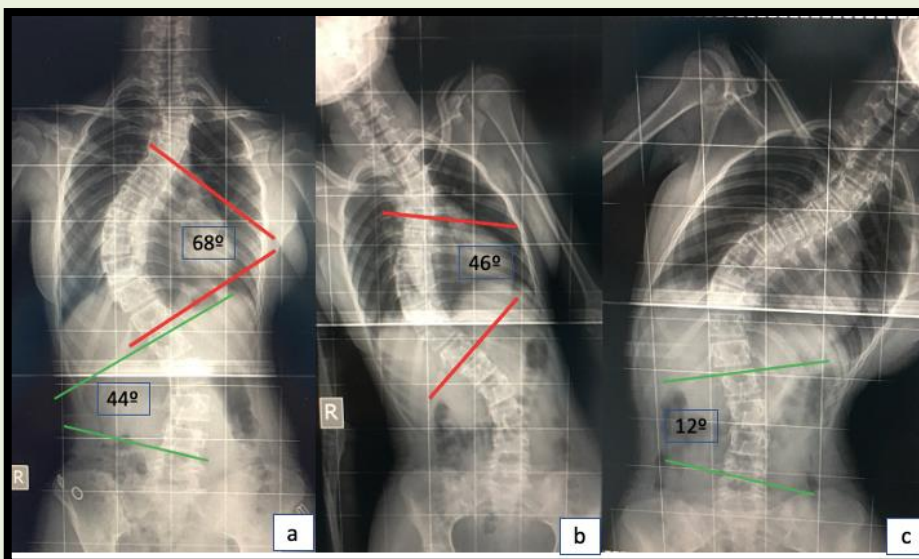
a: Erect radiograph showing a 68° right thoracic and a 44° left lumbar curve. (b, c): On bending the thoracic curve was reducing to 46° and the lumbar curve to 12°.
